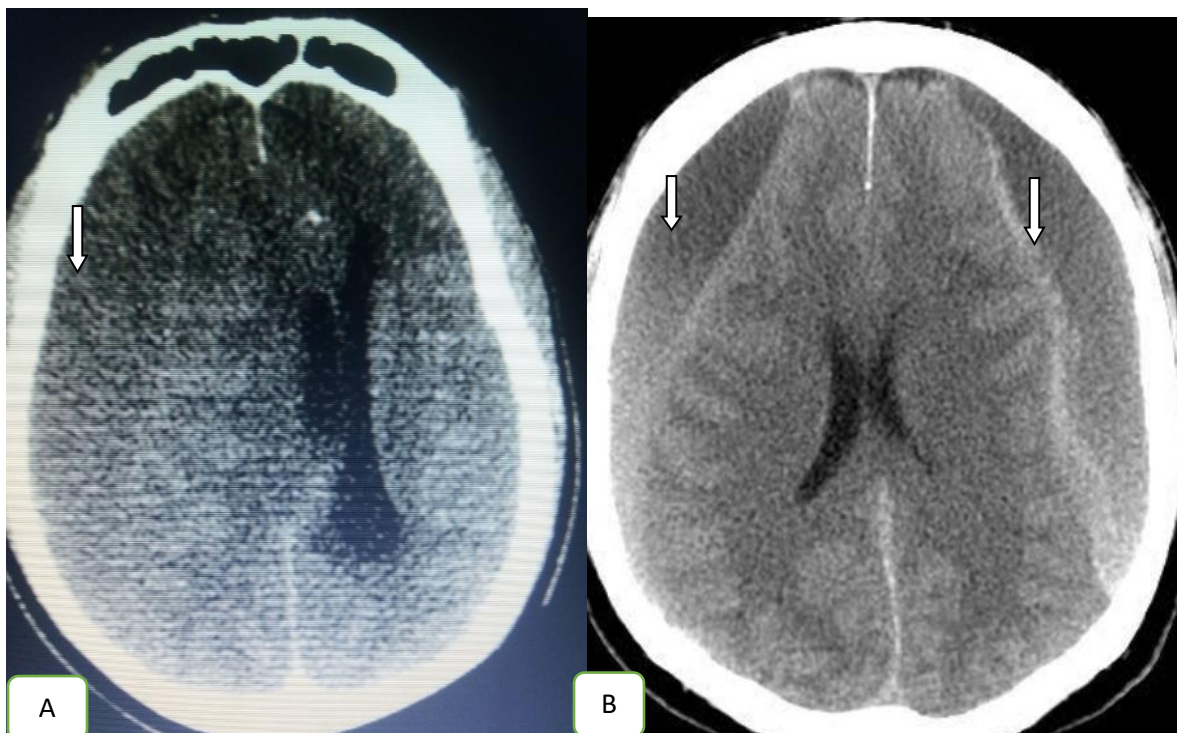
Axial CT scan of the brain at the level of the lateral ventricles showing bilateral crescentic hypodense collection (arrow) due to chronic subdural hematoma.
